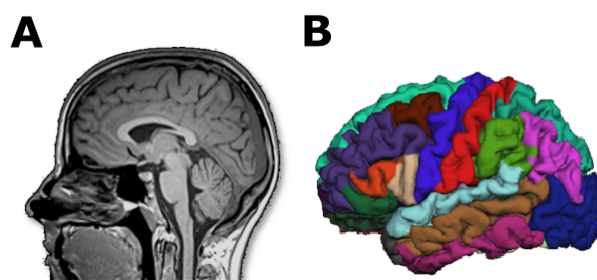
An example of a T1-weighted image and the respective *FreeSurfer* parcellation A: A T1-weighted image, that is, an anatomical brain scan. B: Example of the cortical parcellation performed by *FreeSurfer*.
